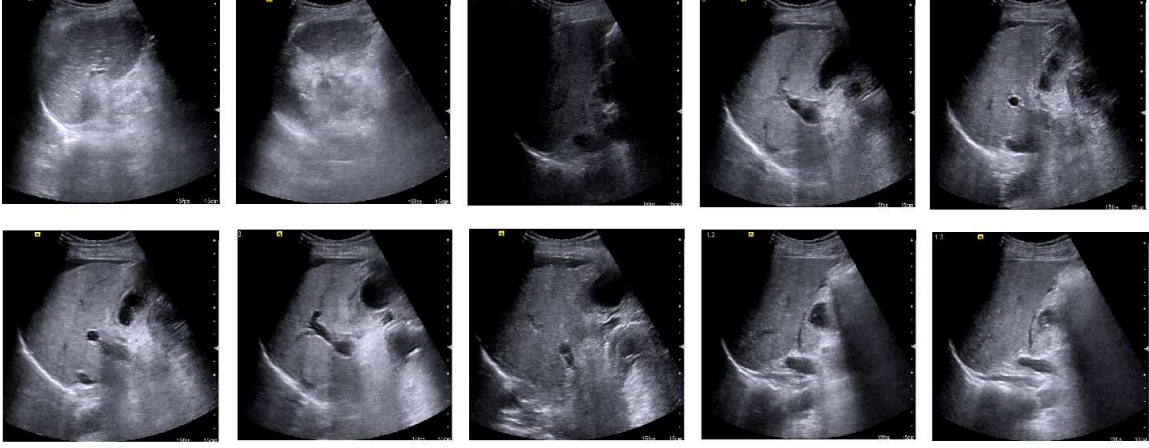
Images sampled from test ultrasound video at a sampling frequency of one second.
